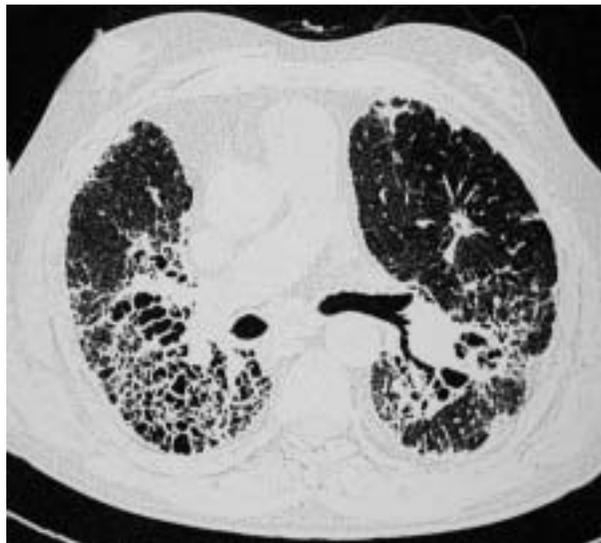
A 62-yr-old male with Sarcoidosis. High-resolution computed tomography scan showing upper lobe end-stage fibrosis with honey combing and traction bronchiectasis. The patient's pulmonary artery is dilated consistent with pulmonary hypertension.
